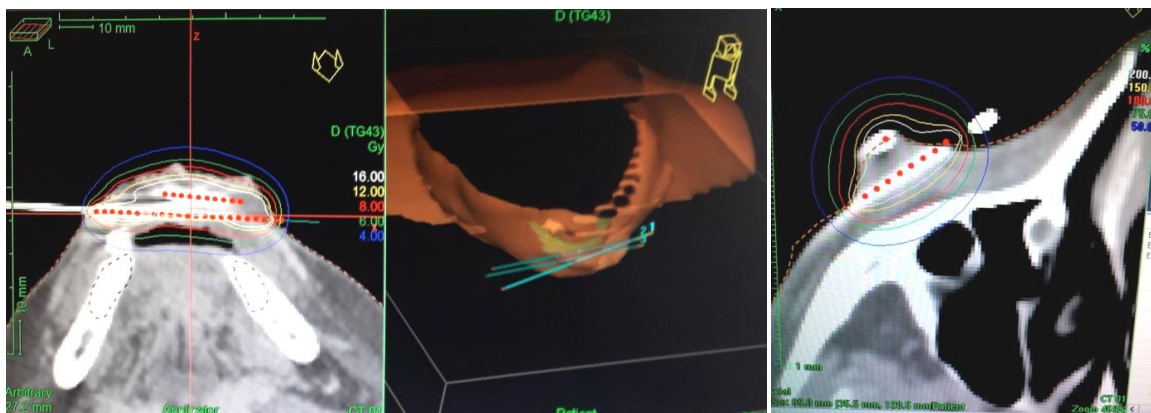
Example of an isodose distribution in 3D CT planning for interstitial HDR brachytherapy of squamous cell carcinoma of the lower lip (left) and basal cell carcinoma of the right cheek (right)
